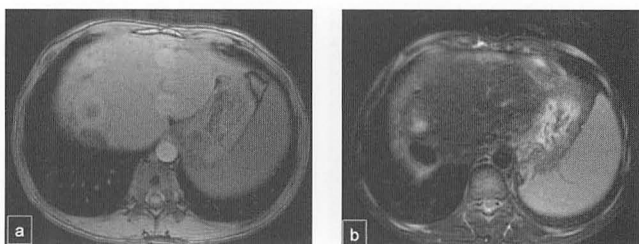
SPIO-MRI image (June 2005)
